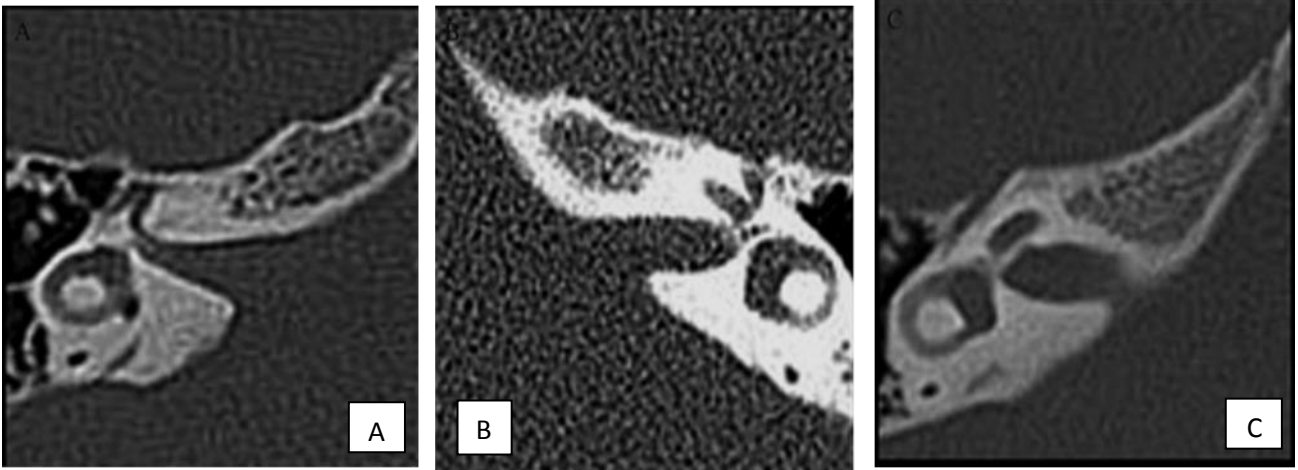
types of shapes observed for the IAC in CT images, A funnel shape, B cylinder shape, C bud shape.
